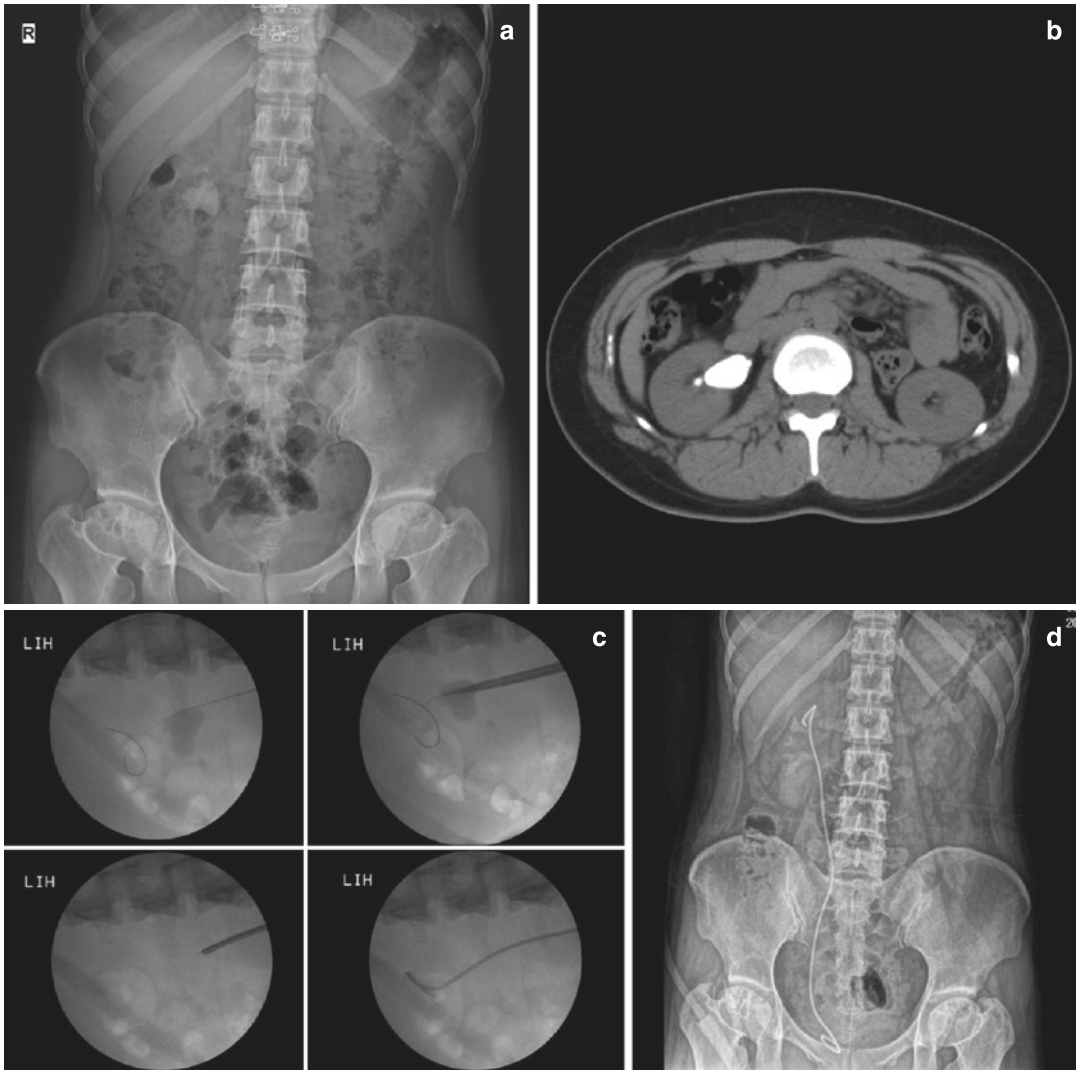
f-URS treated large stone in patient who used anticoagulants. (a) Preoperative KUB showed a 3.5 cm large stone in the right kidney; (b) Preoperative CT scan; (c) Fluoroscopic images during the operation; (d) Postoperative KUB
